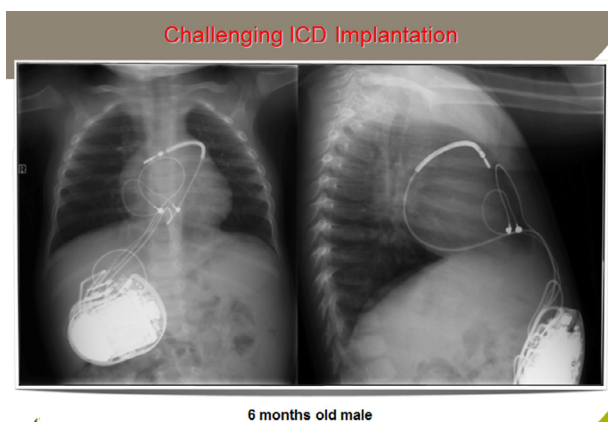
X-ray after ICD implantation in a 6 months old child: Epicardial electrode on epicardial right ventricle free wall, defibrillation electrode around the heart in the sinus transversus. Generator in abdominal position.
